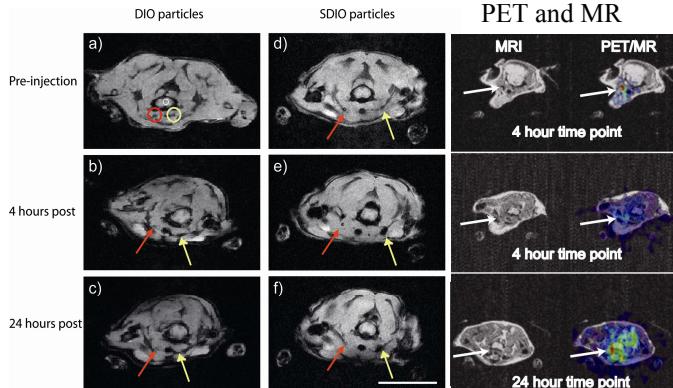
In vivo MRI of SDIO (yellow is ligated carotid)
